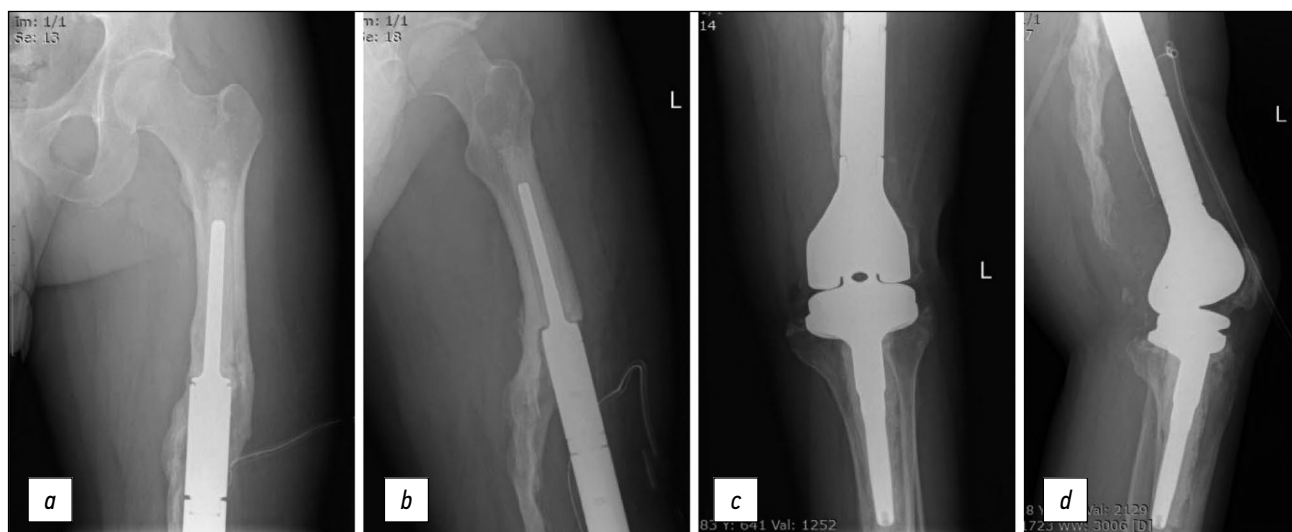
X-ray after stage II knee revision endoprosthesis (2022): *a* — femoral stem of the endoprosthesis, frontal projection; *b* — femoral stem of the endoprosthesis, lateral projection; *c* — tibial pedicle of the endoprosthesis, frontal projection; *d* — tibial pedicle of the endoprosthesis, lateral projection.
